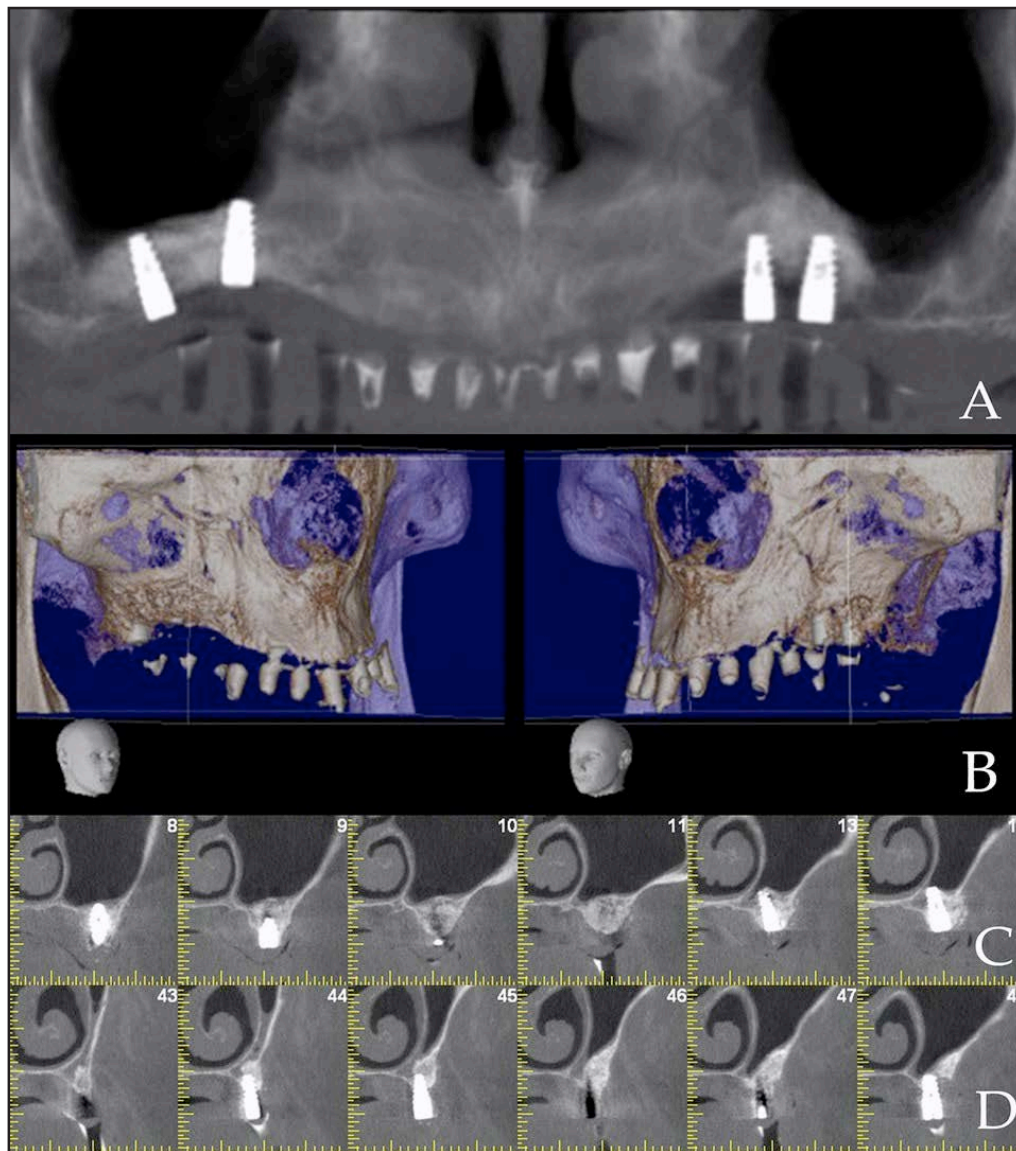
Post-dental implant placement diagnostic images. All images show bone gain in both sides of the maxilla that persisted after the placement of dental implants. A: Panoramic X-ray from a CBCT showing the increase in alveolar bone height and dental implants on the right and left side. B: reconstruction of the left and right maxilla with the surgical stent. C, D: coronal cut from a CBCT scan from the left (C) and right (D) maxilla.
